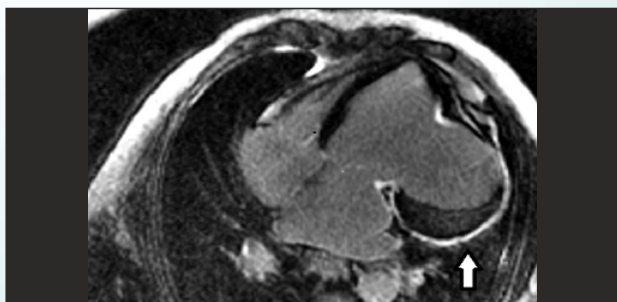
Delayed contrast MRI 4 chamber image showing trans mural enhancement of the aneurysmal wall and no enhancement in rest of myocardium
